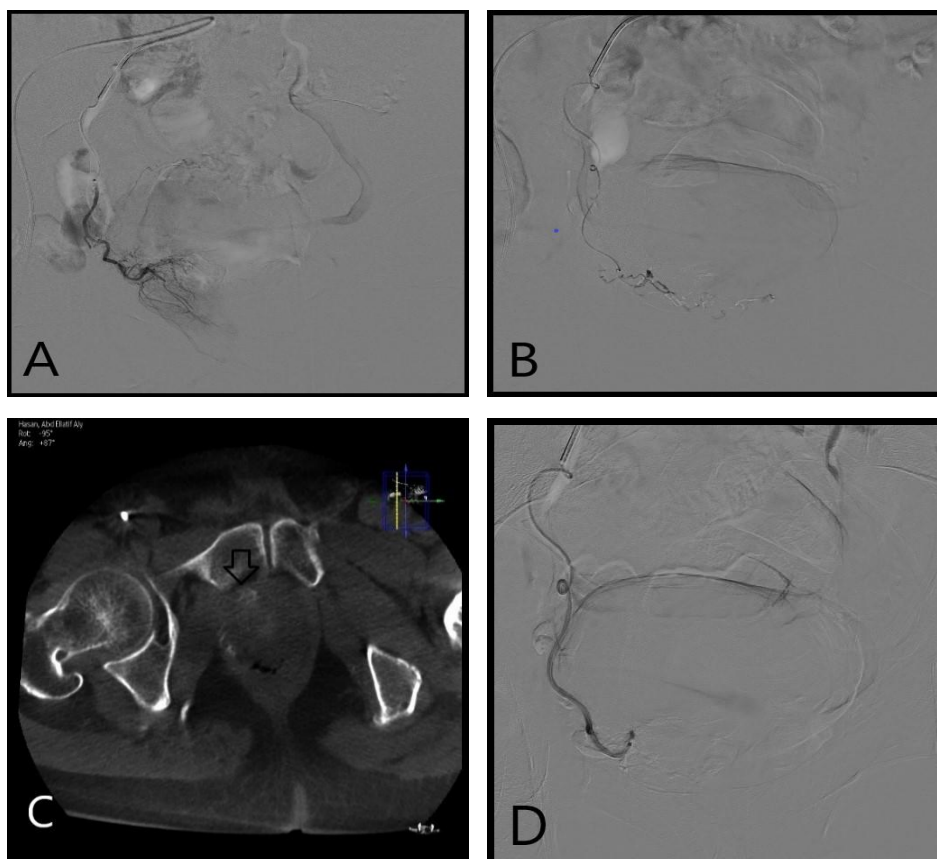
(A) Selective catheterization of the right prostatic artery in right oblique view revealing the prostatic tissue vascularity. (B) Further distal propagation of the microcatheter after more distal embolization. The PErFecTED (Proximal Embolization First, Then Embolize Distal) technique. (C) Cone beam CT after selective prostatic artery catheterization revealing prostatic tissue enhancement. (D) Post-embolization of the right prostatic artery, notice disappearance of the prostatic vasculature. (E) Digital subtraction angiography of the anterior division of the left IIA revealing Origin of the prostatic artery from the upper third of IPA. Type IV. (F) Selective catheterization of the left prostatic artery in Left oblique view.
